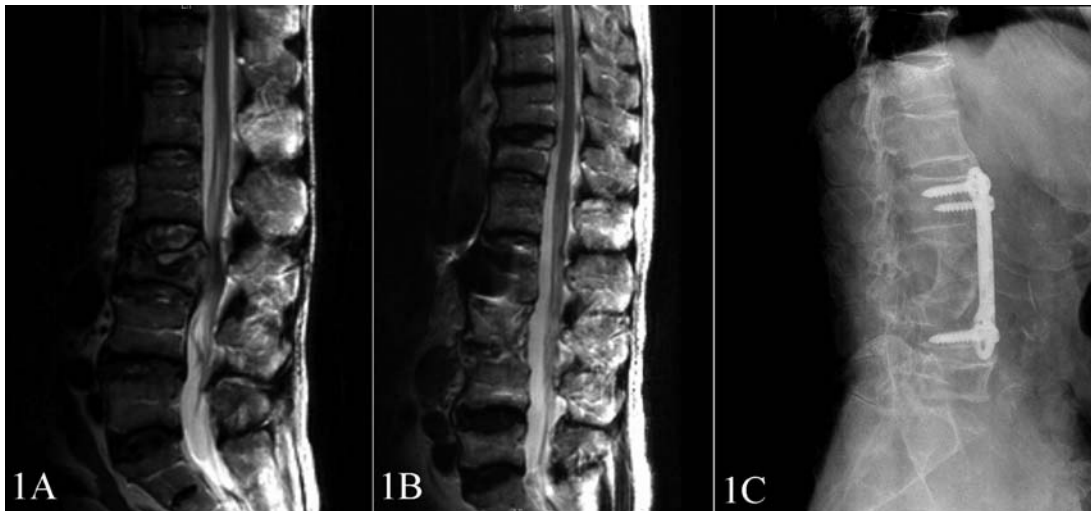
Results of primary non-Hodgkin's lymphoma of L3 treated by surgery and chemotherapy (case 5). (A) MRI views (T2-weighted) show the prominent fracture vertebra with soft tissue mass intruding the spinal canal and compressing the equina cauda. (B) MRI views (T2-weighted) show equina cauda is decompressed completely and no evidence of tumor exists 5 years after treatment. (C) Radiogram shows bone fuse and no evidence of tumor exists 5 years after treatment.
